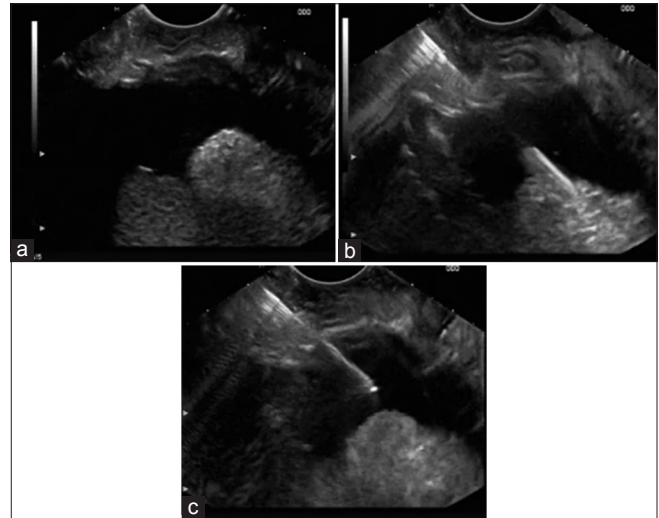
(a) Endoscopic ultrasound shows ascites with peritoneal deposits (b) Endoscopic ultrasound-guided fine needle aspiration of peritoneal deposits through the stomach (c) Endoscopic ultrasound-guided paracentesis of minimal ascites through the stomach
